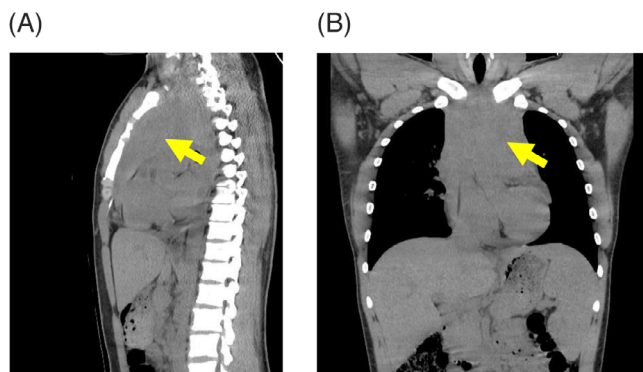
Imaging of the anterior mediastinal tumor. Computed tomography shows a large tumor (arrow) in the anterior mediastinum (A: sagittal image; B: coronal image).
